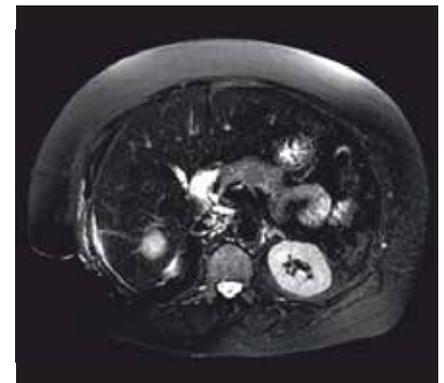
Solitary liver metastases on Triple phase MRI liver
